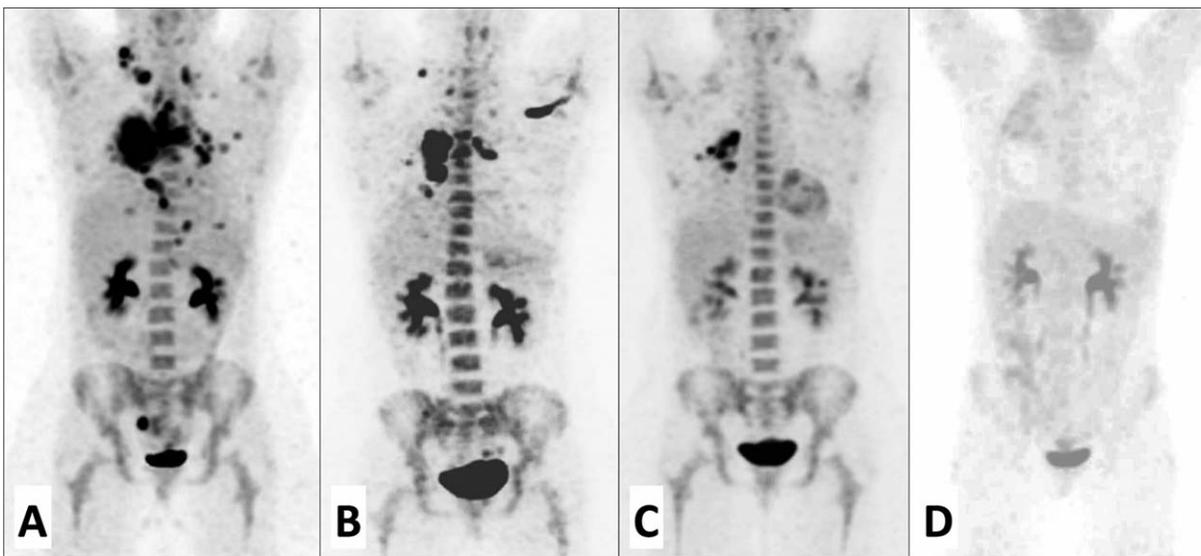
(A) PET/CT scan from February 2010 showing increased FDG avidity above and below the diaphragm before ABVD; (B) PET/CT scan from August 2010 showing increased FDG avidity after 6 cycles of ABVD; (C) PET/CT scan from December 2010 showing increased FDG activity after 3 cycles of ICE; (D) PET/CT scan from December 2011 showing no FDG avidity after 2 cycles of brentuximab vedotin.
